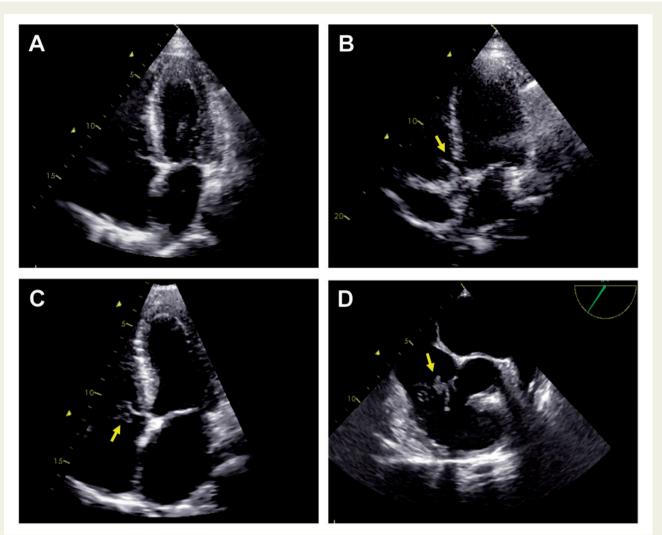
The FoCUS examination by on-call physician did not reveal a potential cause of a cardiac murmur in a young febrile patient (A). Comprehensive echocardiography showed a small ventricular septal defect (B, arrow) along with suspicious tricuspid valve vegetation (C, arrow), which was confirmed by transoesophageal echocardiography (D, arrow). Apical 4-chamber view is shown in panels A. B and C.
